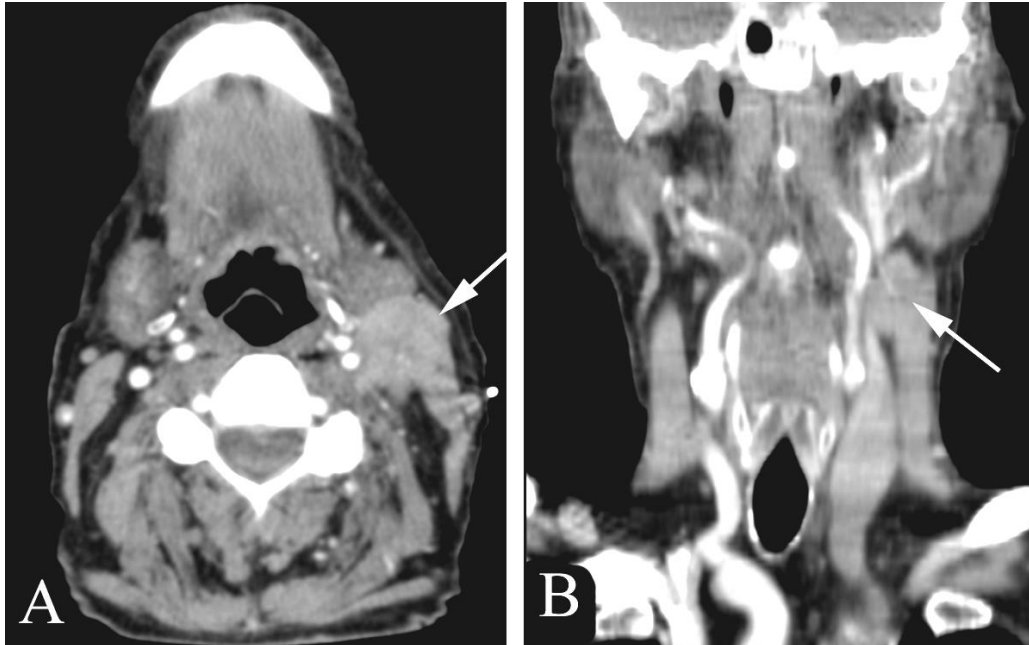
Metastatic squamous cell cancer of the head and neck in a 74 year old man with a palpable neck mass. A. Axial contrast-enhanced neck CT shows a mass (arrow) superficial to the carotid vessels in the left neck, representing metastatic deposit to lymph nodes. Note the marker (white dot) placed along the margin of the palpable lesion by the technologist. B. Coronal reformatted contrast-enhanced CT shows the mass (arrow) superficial to the carotid vessels.
